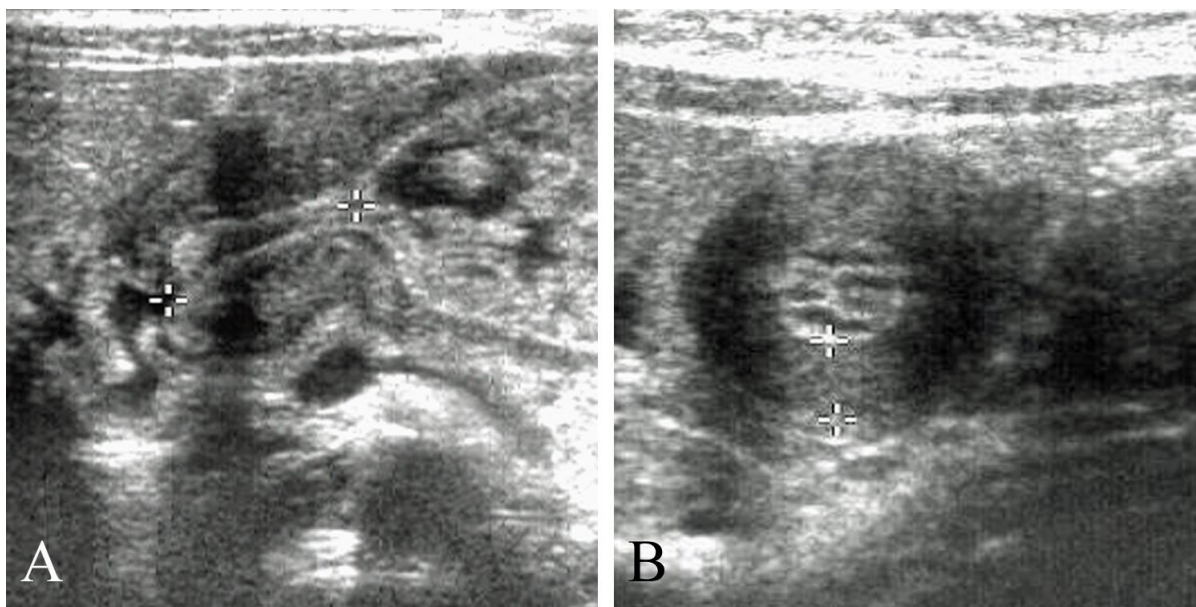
Idiopathic hypertrophic pyloric stenosis (IHPS) in a 2 month old child with vomiting and weight loss. A. Abdominal ultrasound with a longitudinal view of the pylorus (between calipers) shows an abnormally long and thick-walled pyloric channel. B. Abdominal ultrasound transverse view through the pylorus demonstrates an abnormally thick wall (calipers). Case courtesy of Dr. Jeffrey Zapolsky, Radiology Associates of the Fox Valley.
